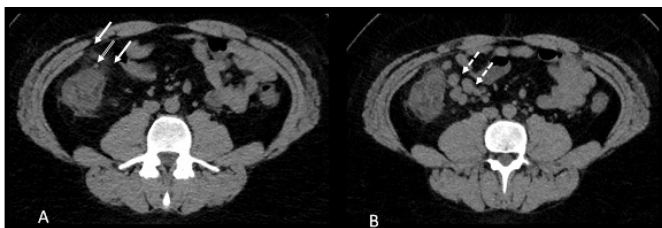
Abdominal computed tomography image of our case. A; At the level of the ileocecal junction, a lesion measuring 25x20 mm in fat density with a hyperdense focus (hollow arrow) in the center, high-density rim in its anterior neighborhood, and inhomogeneity compatible with inflammation in the surrounding mesenteric fatty tissue. B; adjacent mesenteric lymph nodes (dashed arrow)
